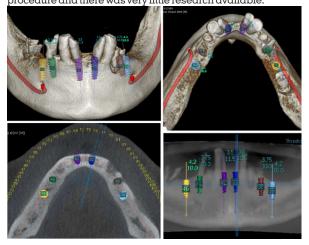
CBCT Scan Of Mandible With Implant Visualization
